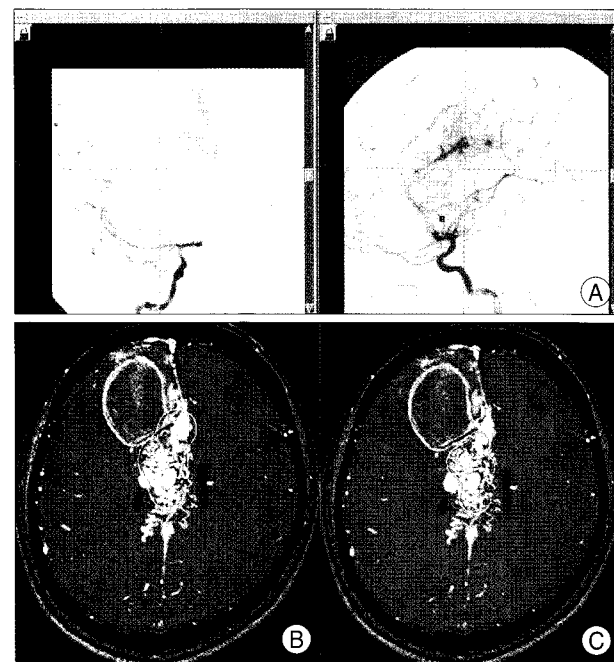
An example of serial methods to minimize target volume is shown using Gamma Plan. A : Projective volume of nidus on conventional angiography. B : Primary target volume on TOF MR images. C : Minimized real target volume excluding draining vein and supplying arteries.
